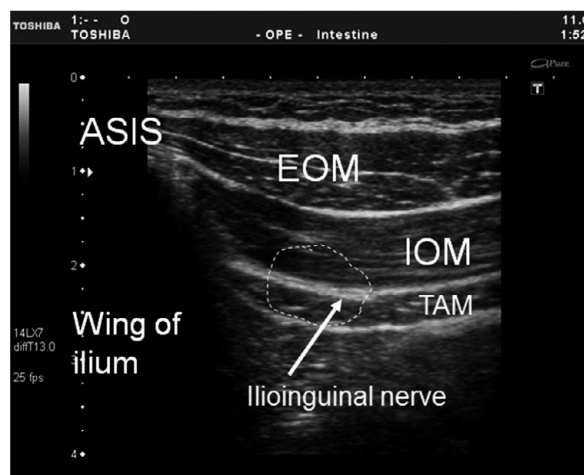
Ultrasound ilioinguinal nerve block. ASIS, anterior superior iliac spine; EOM, external oblique muscle; IOM, internal oblique muscle; TAM, transversus abdominal muscle. Reproduced with permission from Arthurs G, Nicholls B (eds.) 2016. *Ultrasound in Anesthesia, Critical Care, and Pain Management*. Cambridge, UK: Cambridge University Press
